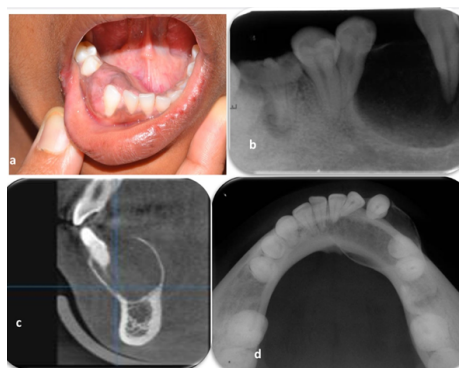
Preoperative Clinical Pictures & Radiographs
